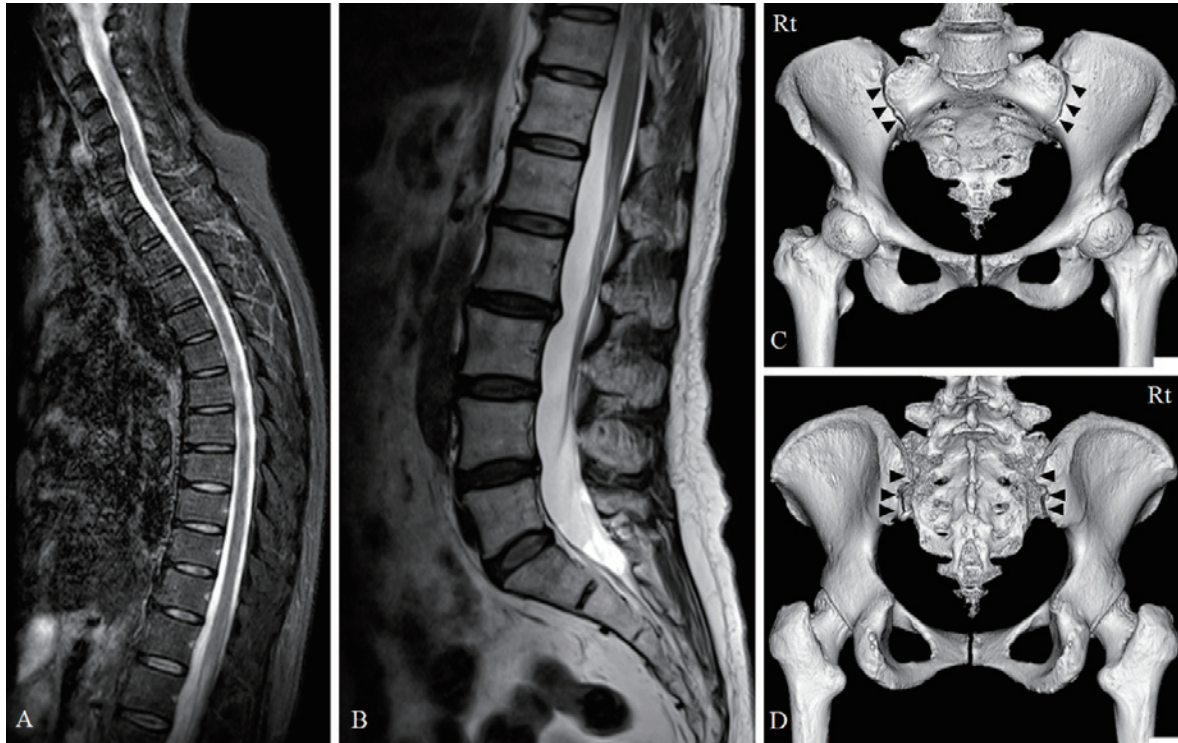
A, B: Magnetic resonance T2-weighted images of the spinal cord show no obvious lesions causing the pain. C, D: 3D images of pelvic computed tomography show no obvious abnormalities in the sacroiliac joints (arrowheads: sacroiliac joints, C: anterior-posterior view, D: posterior-anterior view).
